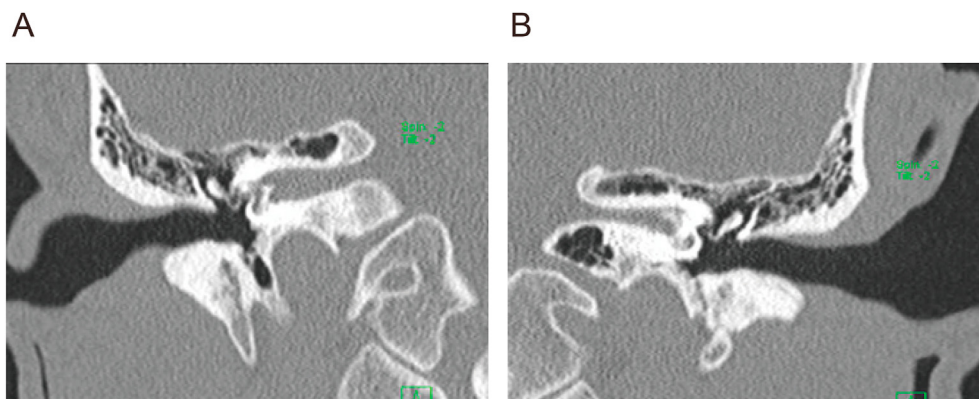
Computed tomography of inner ear. (A) right inner ear, (B) left inner ear.
